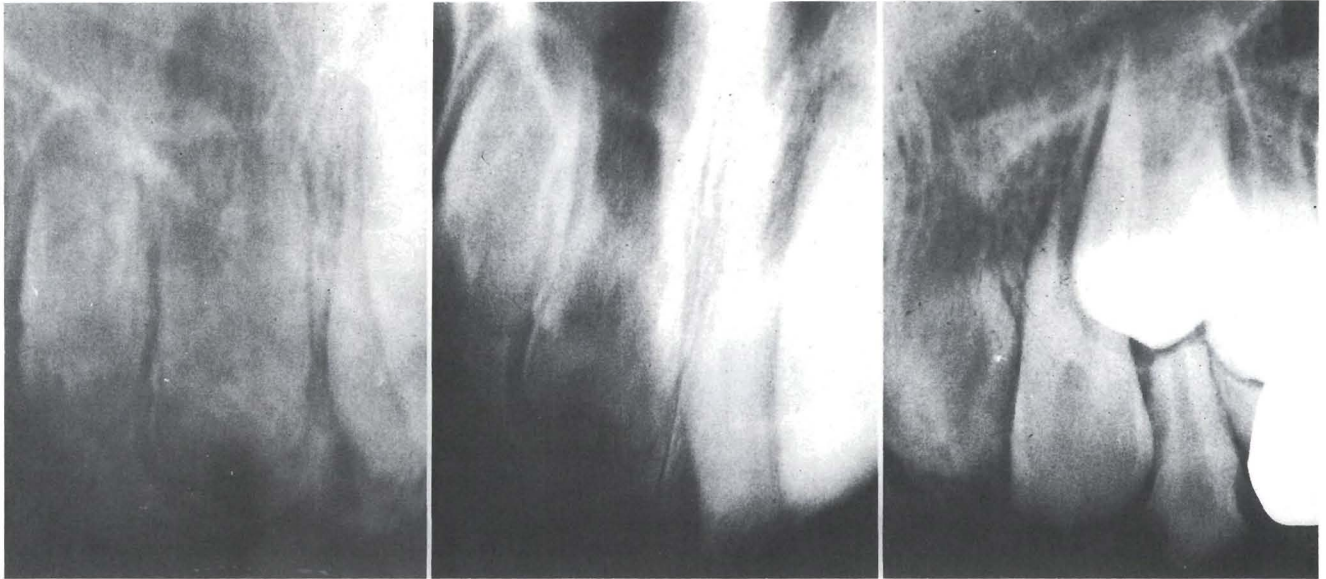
X-ray appearance ("ghost teeth") of maxillary permanent incisors. Note unaffected maxillary left permanent lateral incisor.
